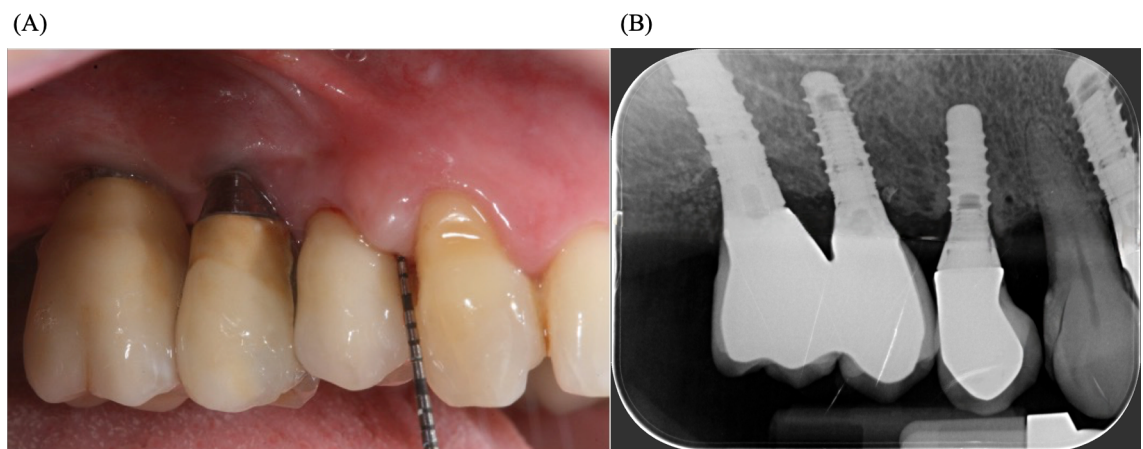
Clinical finding of bleeding on probing (A) and absence of radiographic bone loss (B), allowing the diagnosis of peri-implant mucositis.
